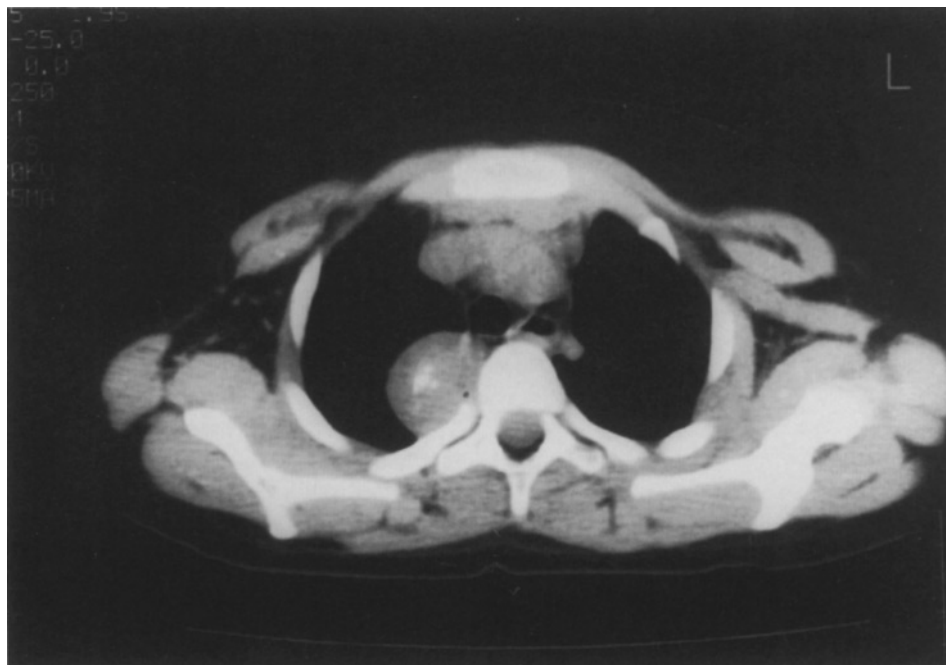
CT scan of the chest. A thoracic paraspinal mass with central calcification is visible.
